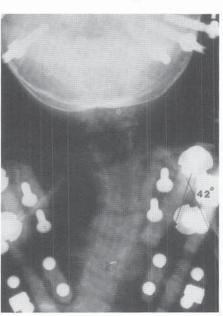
Klippel-Feil syndrome with torticollis. A and B, Clinical appearance of a 13-month-old toddler. Note the fixed head tilt, low hairline, and plagiocephaly. C, Initial radiograph obtained at age 5 months showing right convex scoliosis due to multiple congenital anomalies. D, Radiograph obtained at age 13 months showing progression of the deformity. A significant compensatory thoracolumbar curve has developed. E, The rotational deformity extended to C5. F, Anterior fusion was extended via a thoracotomy to the C6–7 disk through the chest (*arrows* point to the convex bone graft). Posterior fusion was extended to C5–T8.
